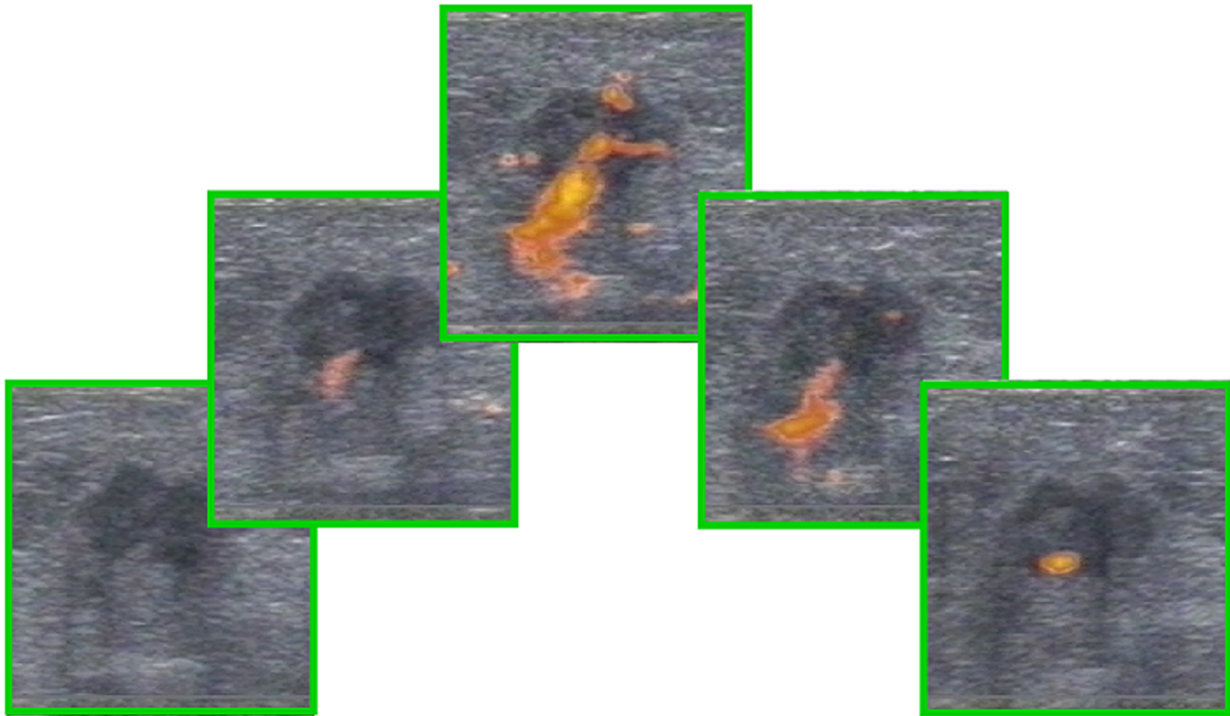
Sequential ultrasonographic images with power Doppler interrogation depicting the arrival of a bolus of microbubble contrast agent at a malignant tumour (figure courtesy of Dr E Moskovic, Royal Marsden Hospital). Note typical malignant tumour vascularisation.
